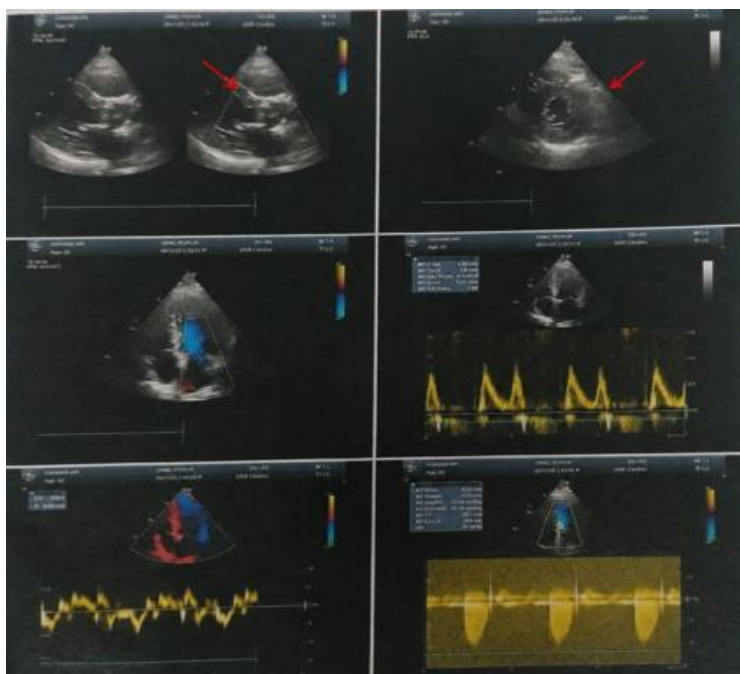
shows the Echocardiography picture highlighting the presence of the vegetation seen attached to the prosthetic aortic valve
